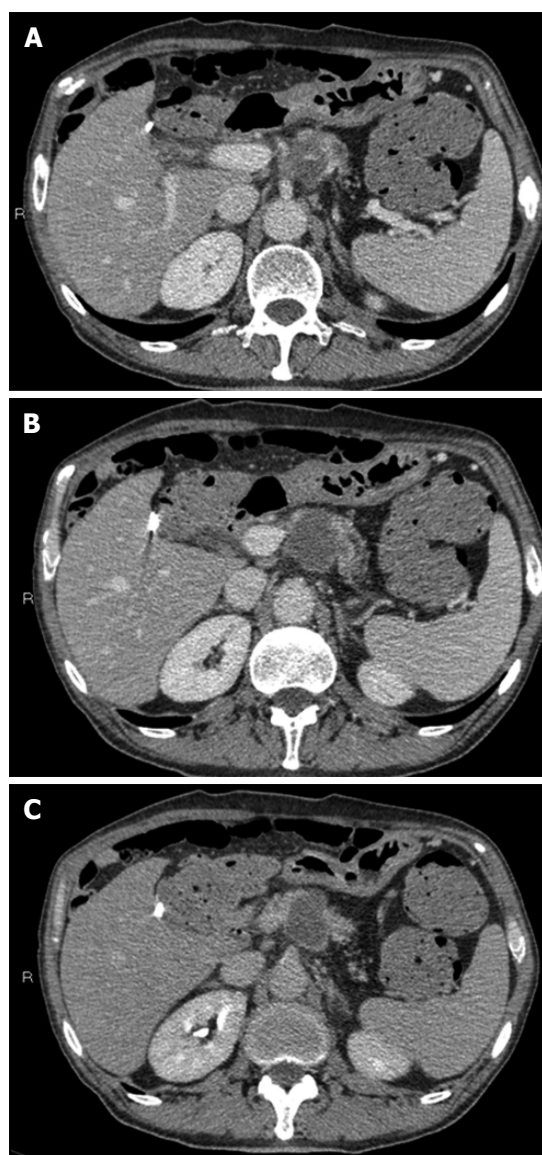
Radiofrequency ablation of pancreatic cancer. Computed tomography (CT) scan in the portal phase (A, B) shows the markedly hypodense necrotic avascular area modelled within the tumor. CT scan in the late phase (C) shows the ablated area as being better delineated from the enhanced adjacent tissue.
